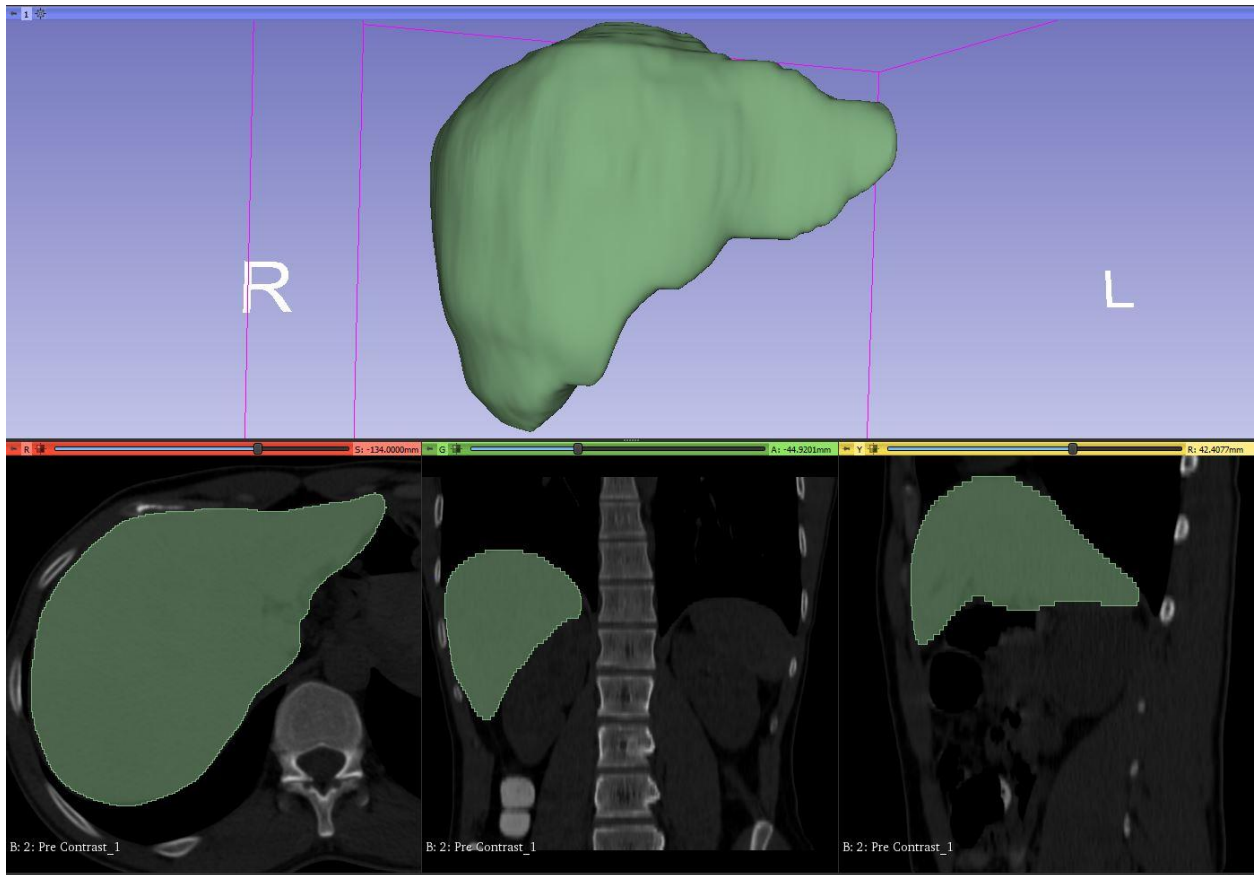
Segmented liver from the volumetric CT image and the created 3D model.
